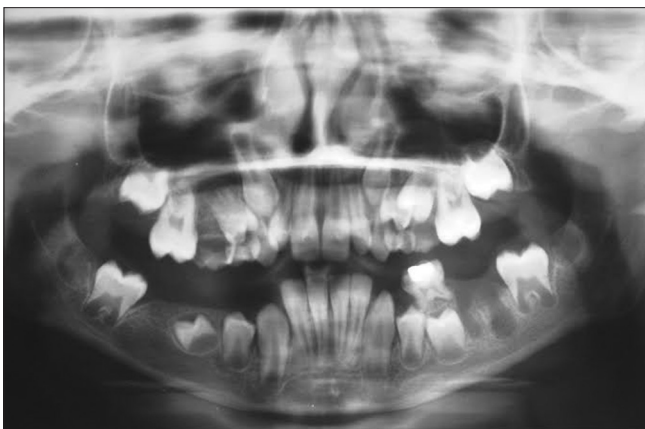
Panoramic radiograph of the patient showing the ghostly appearance of the maxillary right and left deciduous second molar
